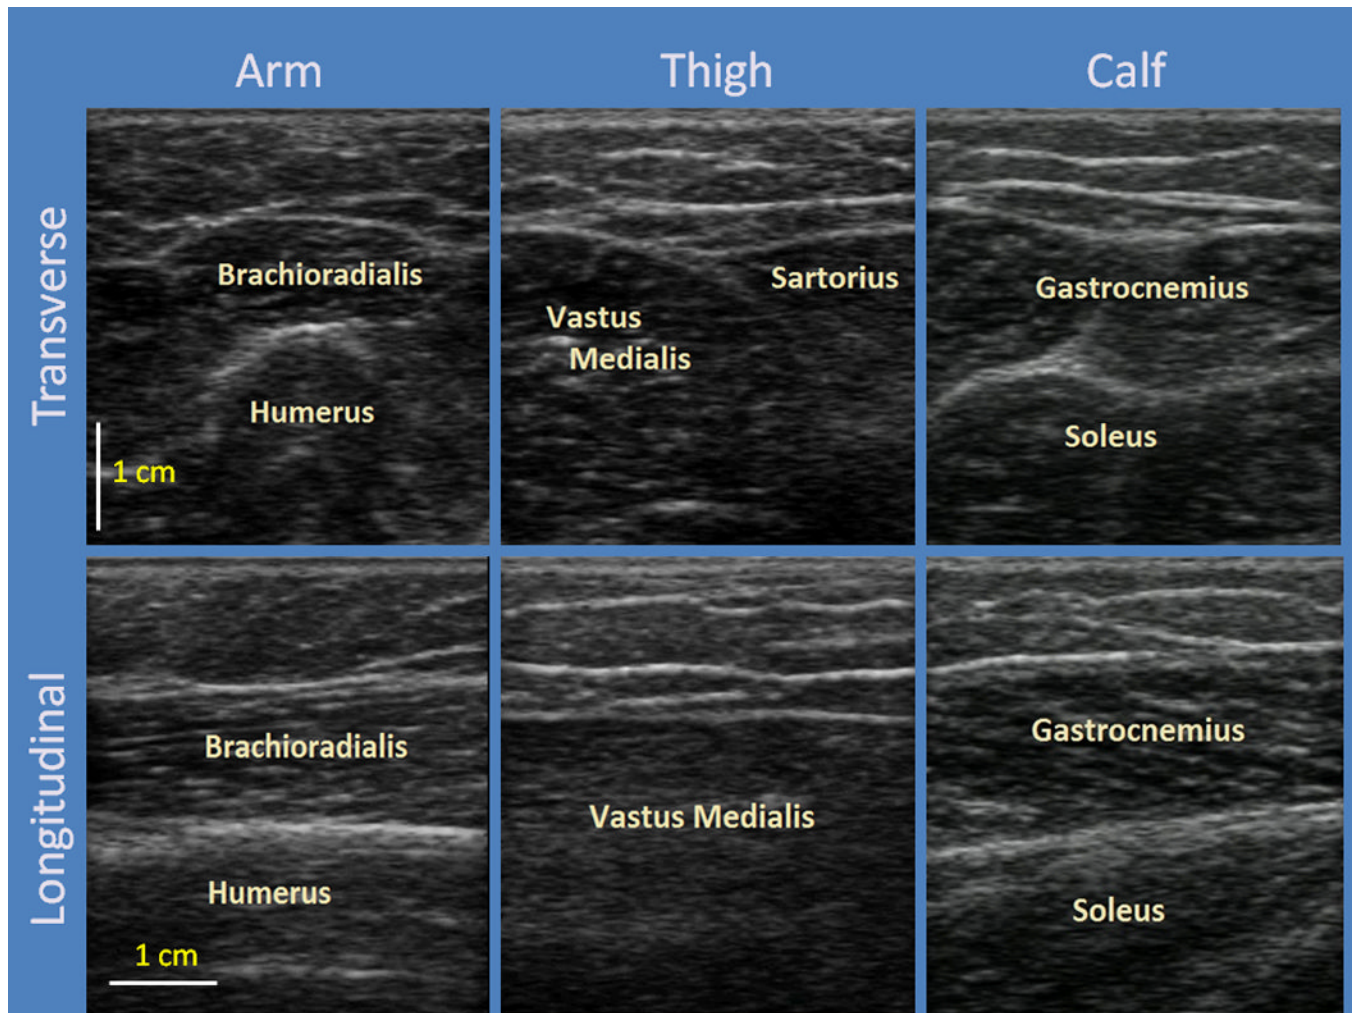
Ultrasound Images of the Three Body Locations. Arm (*left column*), Thigh (*middle column*), and Calf (*right column*). Images in the first row are transverse-oriented images while those in the second row are longitudinal-oriented.
